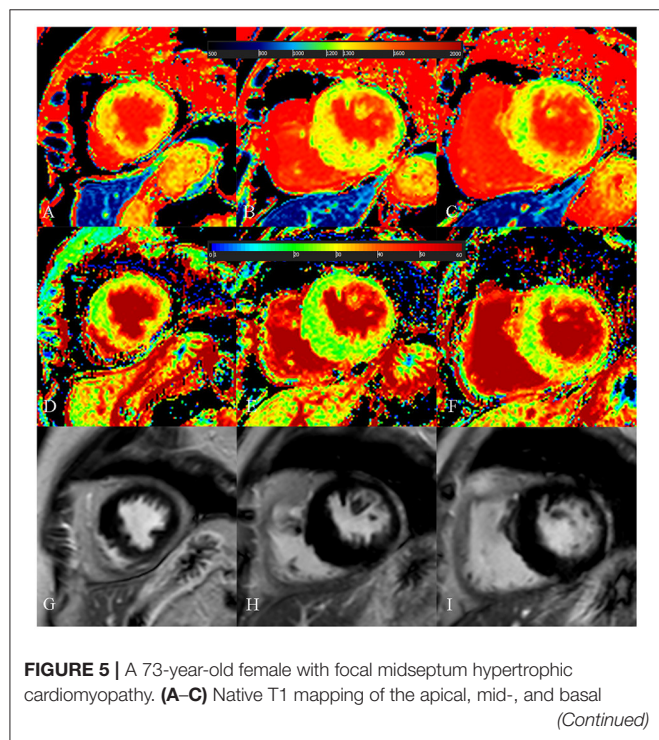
portions of the left ventricular (LV) myocardium showed increased global native T1 (1,335.03 ms). (D–F) Extracellular volume fraction (ECV) of the apical, mid-, and basal portions of the LV myocardium showed normal global ECV (26.9%). (G–I) Late gadolinium enhancement (LGE) images of the apical, mid-, and basal portions of the LV myocardium showed no LGE. The maximal LV wall thickness was 19.8 mm, left atrial diameter was 40 mm, and the LV outflow tract gradient pressure was 95 mmHg. She had no family history of sudden cardiac death (SCD), non-sustained ventricular tachycardia, unexplained syncope, LGE/LV mass ≥ 15%, end-stage systolic dysfunction, and apical aneurysm. She was stratified as having low SCD risk under the 2014 European Society of Cardiology guidelines (5-year SCD probability: 1.70%) and enhanced American College of Cardiology/American Heart Association guidelines. However, she underwent cardiac-caused death 26 months after cardiac MRI examination. The elevated global native T1 mapping values could help indicate poor outcome in patients with low risk according to the two guidelines.
